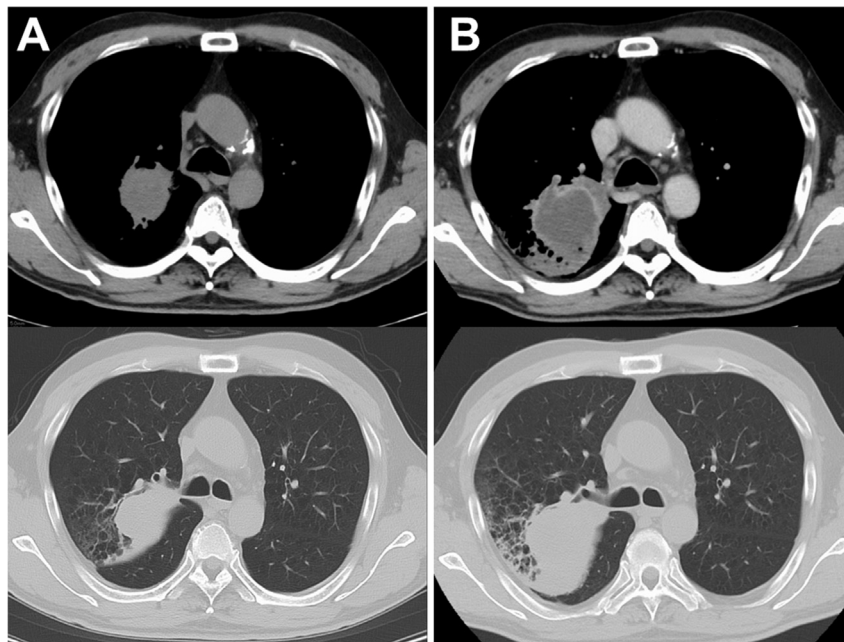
A: Chest computed tomography image obtained before bronchoscopy showing an irregularly shaped mass 45 mm diameter in the right S2. The bronchus adjacent to the tumor was obstructed. B: Contrast-enhanced computed tomography performed 7 days after the examination showing an increased size of the mass with rim enhancement.
